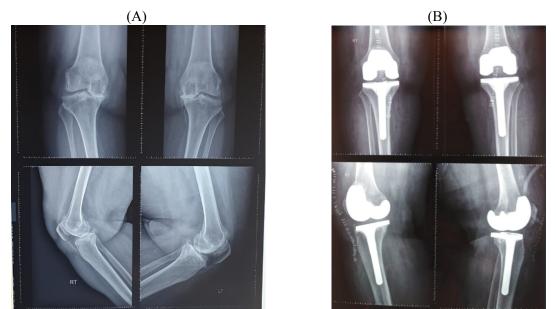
Preoperative (A) and postoperative (B) radiographs of one of the patients who had severe varus deformity.
